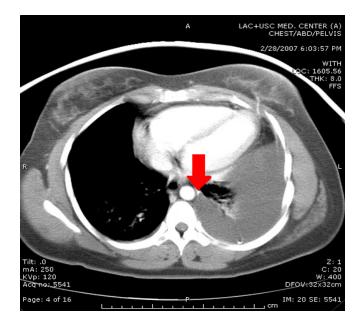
Computed tomography chest demonstrating the tip of the ventriculo-peritoneal shunt catheter adjacent to the aorta.
